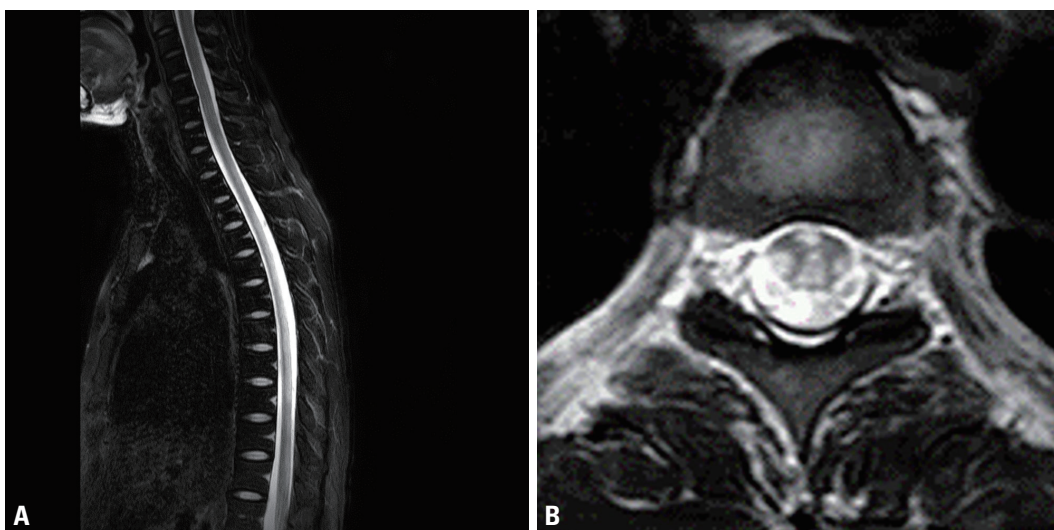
T2-weighted spinal magnetic resonance imaging (patient no. 9). (A) T2-weighted sagittal image, indicating high signal intensities within the posterior spinal cord from C7 to the conus medullaris. (B) T2-weighted axial image indicating high signal intensities in the anterior, lateral, and posterior spinal column.
